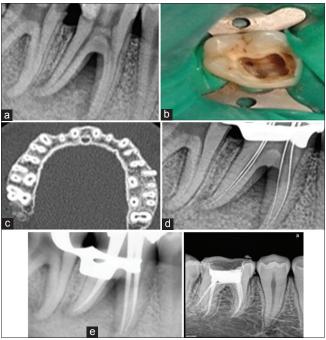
Pre-operative intraoral periapical of 46, (a) Preoperative, (b) access opening, (c) spiral computed tomography, (d) working length, (e) master cone
